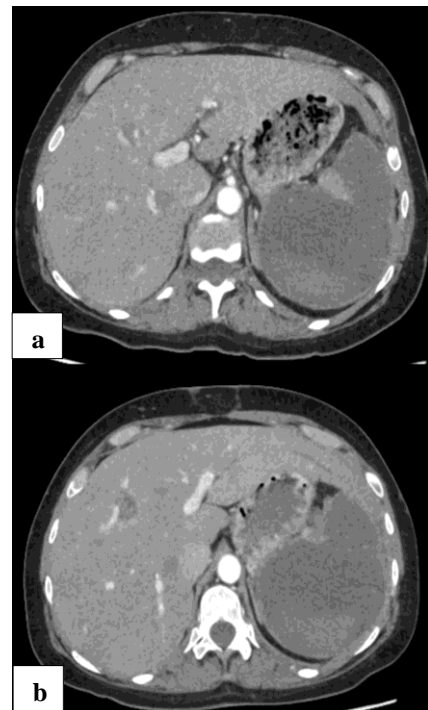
Follow up axial CT imaging showing spontaneous thrombosis of hepatic artery aneurysm – (a) taken on 22 October 2024 and (b) taken on 25 October 2024.
